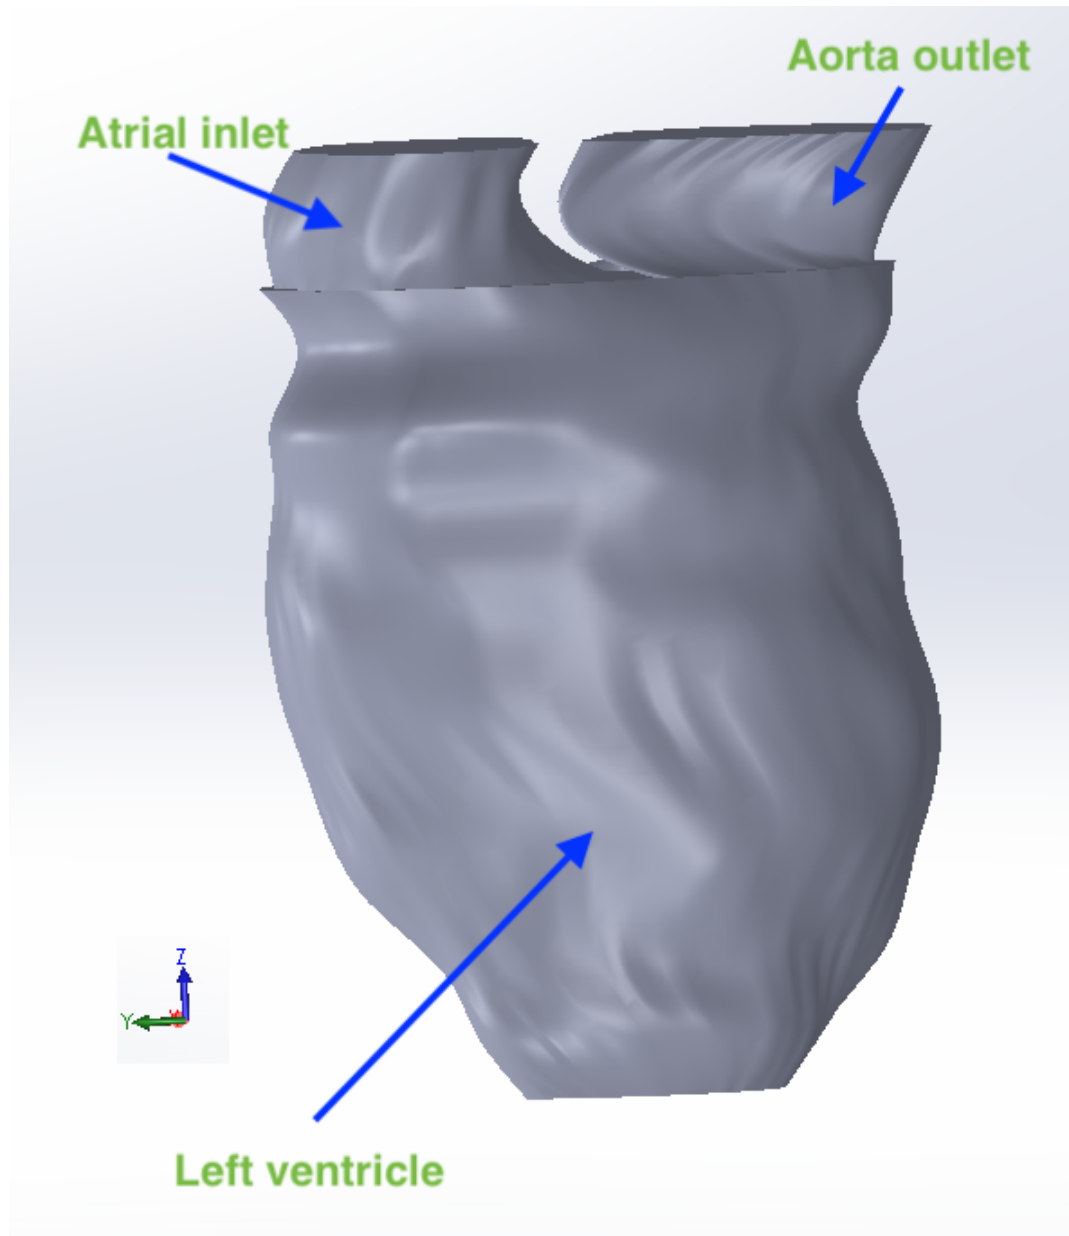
Patient-specific volume geometry of left ventricle with aorta outlet and atrial inlet reconstructed from 2D MRI images.
